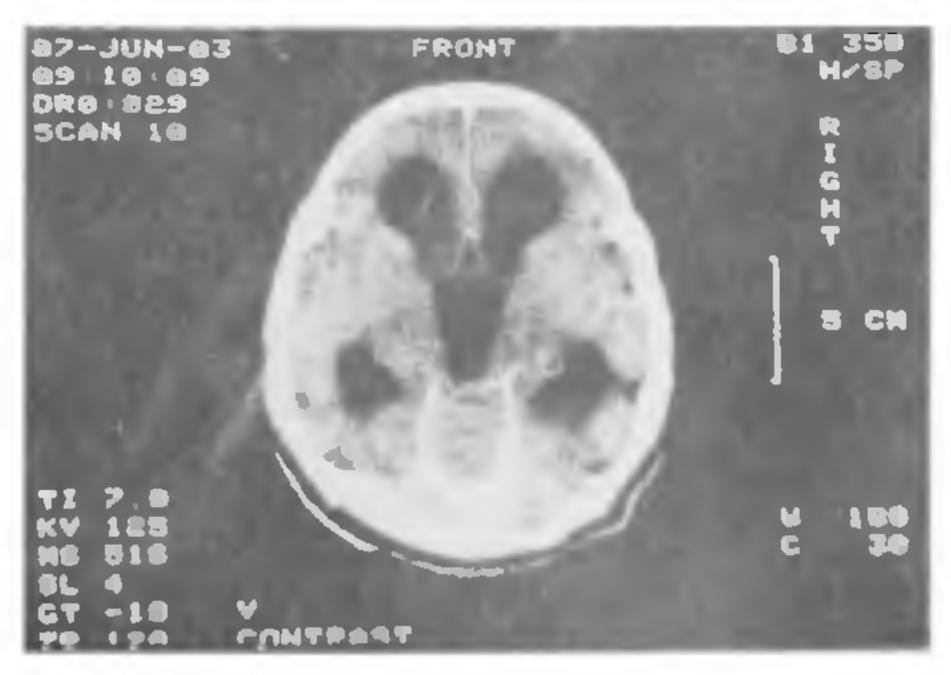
Axial CT scan of the brain of a girl aged 18 years with progressive mental deterioration showing marked hydrocephalic dilatation of the lateral and third ventricles. The latter is tapering posteriorly to a point where there was aqueduct stenous, not seen here. The cortical sulcitate effaced
